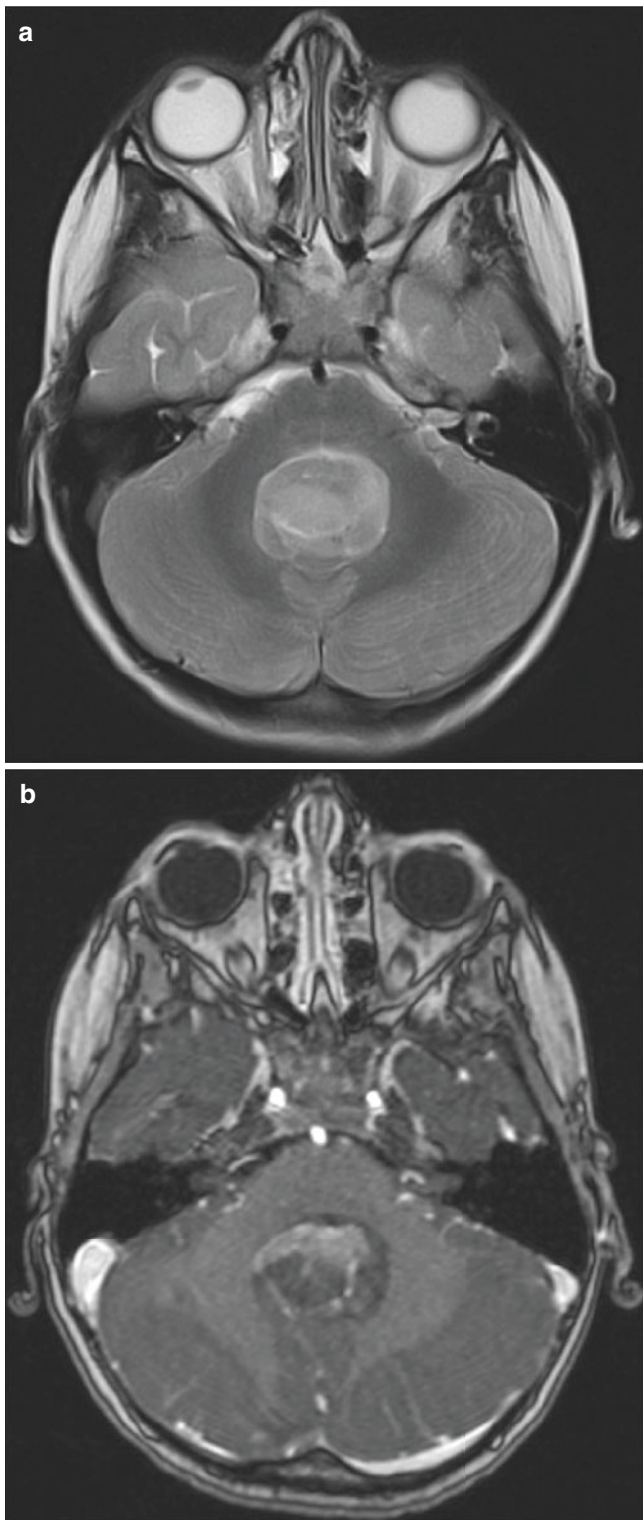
Medulloblastoma. (a) Axial T2-weighted MR image shows a lesion of intermediate signal intensity in the cerebellar vermis, compressing the fourth ventricle. (b) Axial post-contrast T1-weighted image shows inhomogeneous contrast enhancement within the mass
